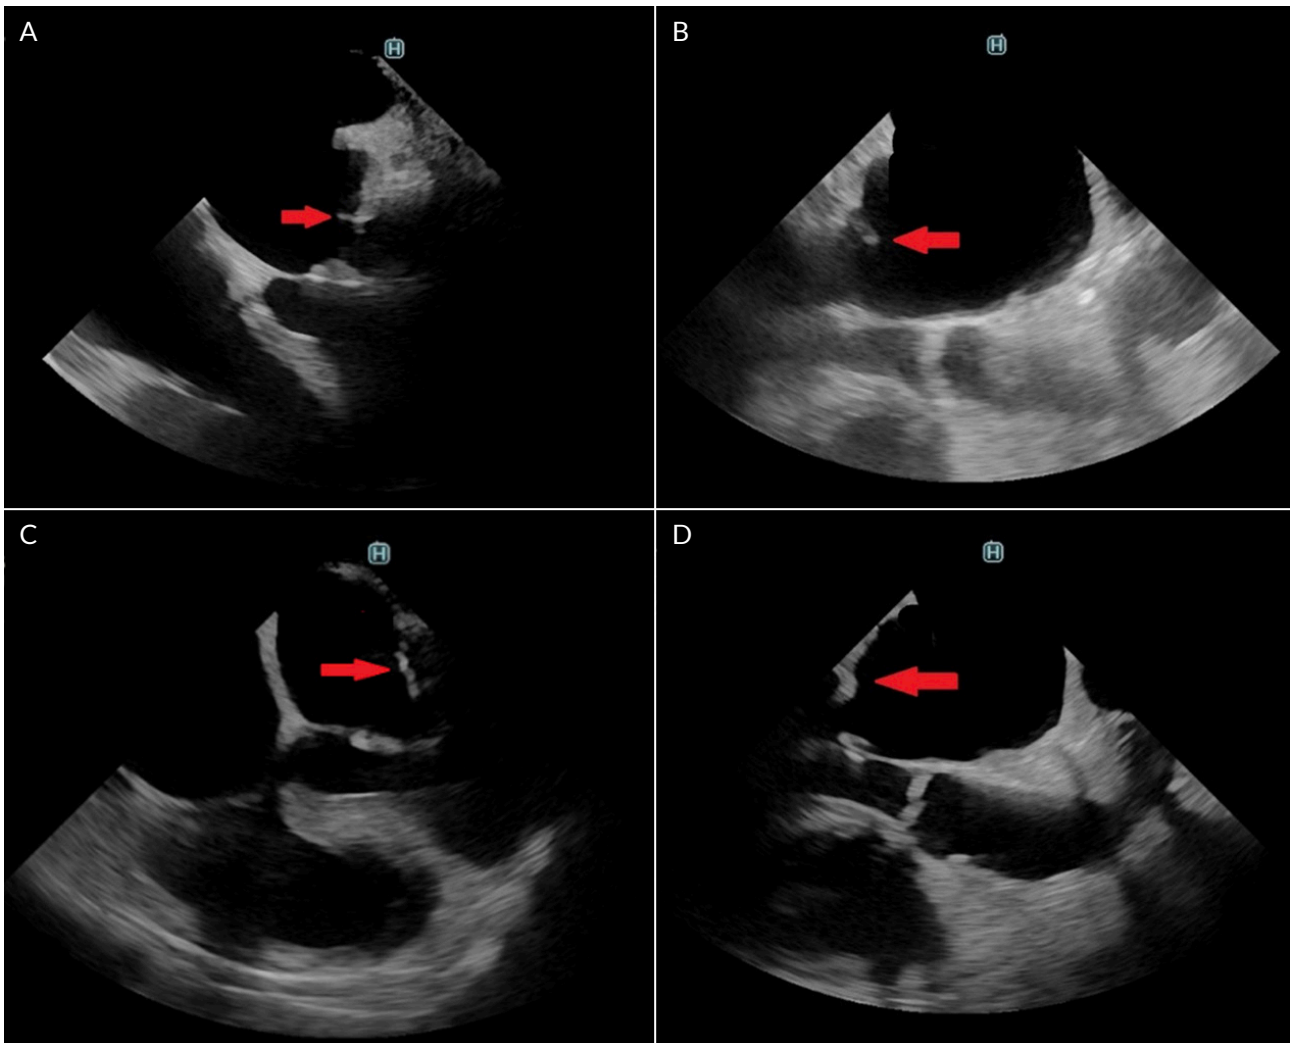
Transoesophageal echocardiography. A) a vegetation of the posterior leaflet of the mitral valve; B) long axis view of the left ventricle showing a vegetation of the posterior leaflet of the mitral valve; C) four-chamber view with no vegetation of posterior leaflet of the mitral valve after treatment; D) long-axis view of the left ventricle with no vegetation of posterior leaflet of the mitral valve after treatment.
